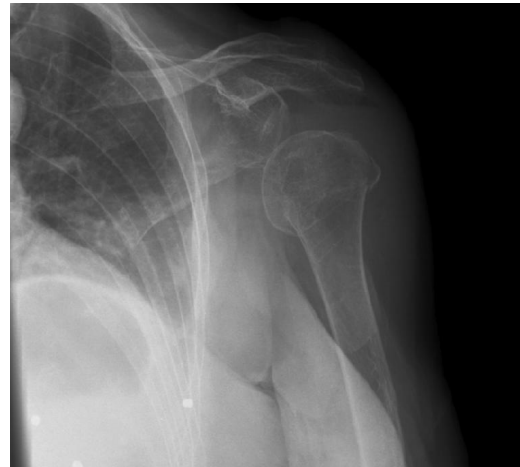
X-ray: impacted surgical neck fracture
